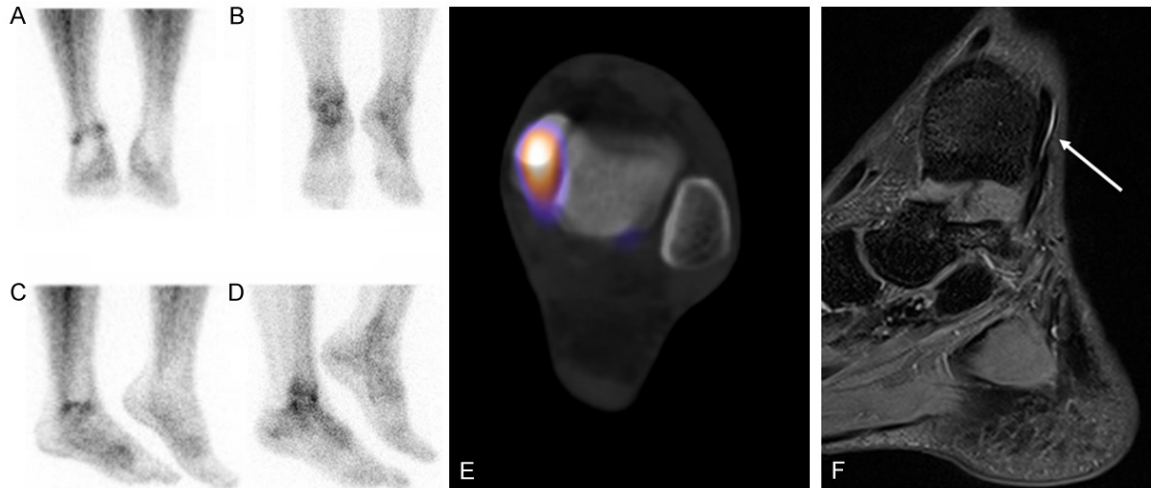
Posterior (A) and lateral (C) blood pool images demonstrate mild increased uptake over the left malleoli, consistent with mild hyperemia. Delayed planar posterior (B), lateral (D) and axial SPECT-CT (E) images show focal increased activity at the inferior aspect of medial malleolus, suggestive of malleolar periostitis due to posterior tibiotalis tendinosis. Sagittal PD fat suppressed weighted image (F) from subsequent MRI confirmed edema with mild tendinosis of the inframalleolar portion of the posterior tibial tendon (arrow).
